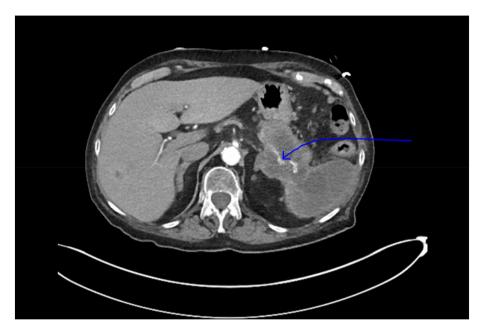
Contrast Enhanced CT scan showing splenic artery (blue arrow) being encased by a large heterogeneously enhancing mass within the pancreatic tail measuring 7.6×6.3 cm leading to splenic infraction.
